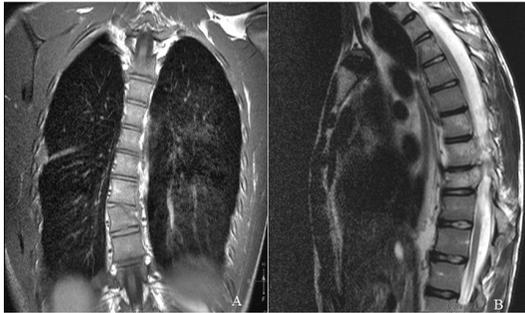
Magnetic resonance images showing a burst fracture in the T9 vertebra (A) and compression fractures at T7-T8 vertebrae (B), without significant cord injury.
